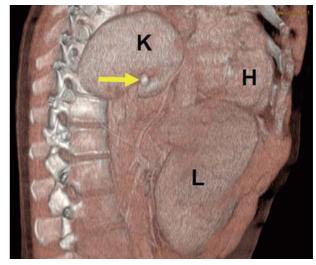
Sagittal CT scan shows appendicolith in the appendicular lumen in the retroperitoneal space on the Th9/Th10 level (yellow arrow), below the kidney and above the liver. K: Kidney; L: Liver; H: Heart.
